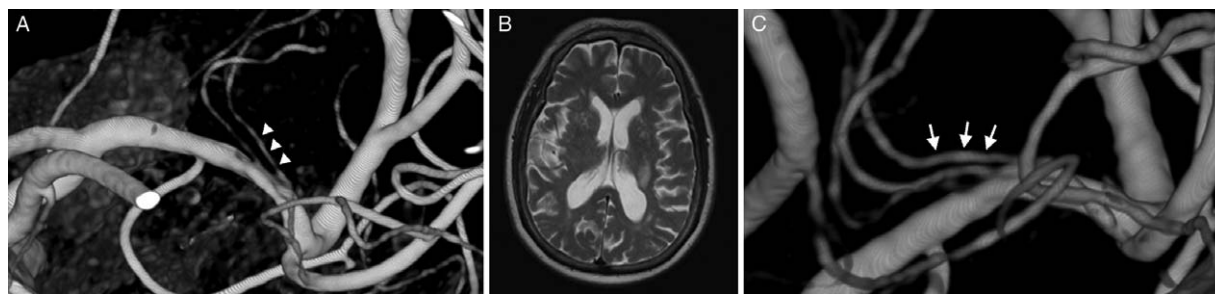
Three-dimensional rotational angiography (3DRA) of the left middle cerebral artery showing possible perforator stenosis (A, white arrowheads) in a patient with white matter hyperintensities in T2 MRI (B). (C) Follow-up 3DRA showed possible regression in perforator stenosis (white arrows) after 1 year of intensive medical therapy. MRI: Magnetic resonance imaging.
